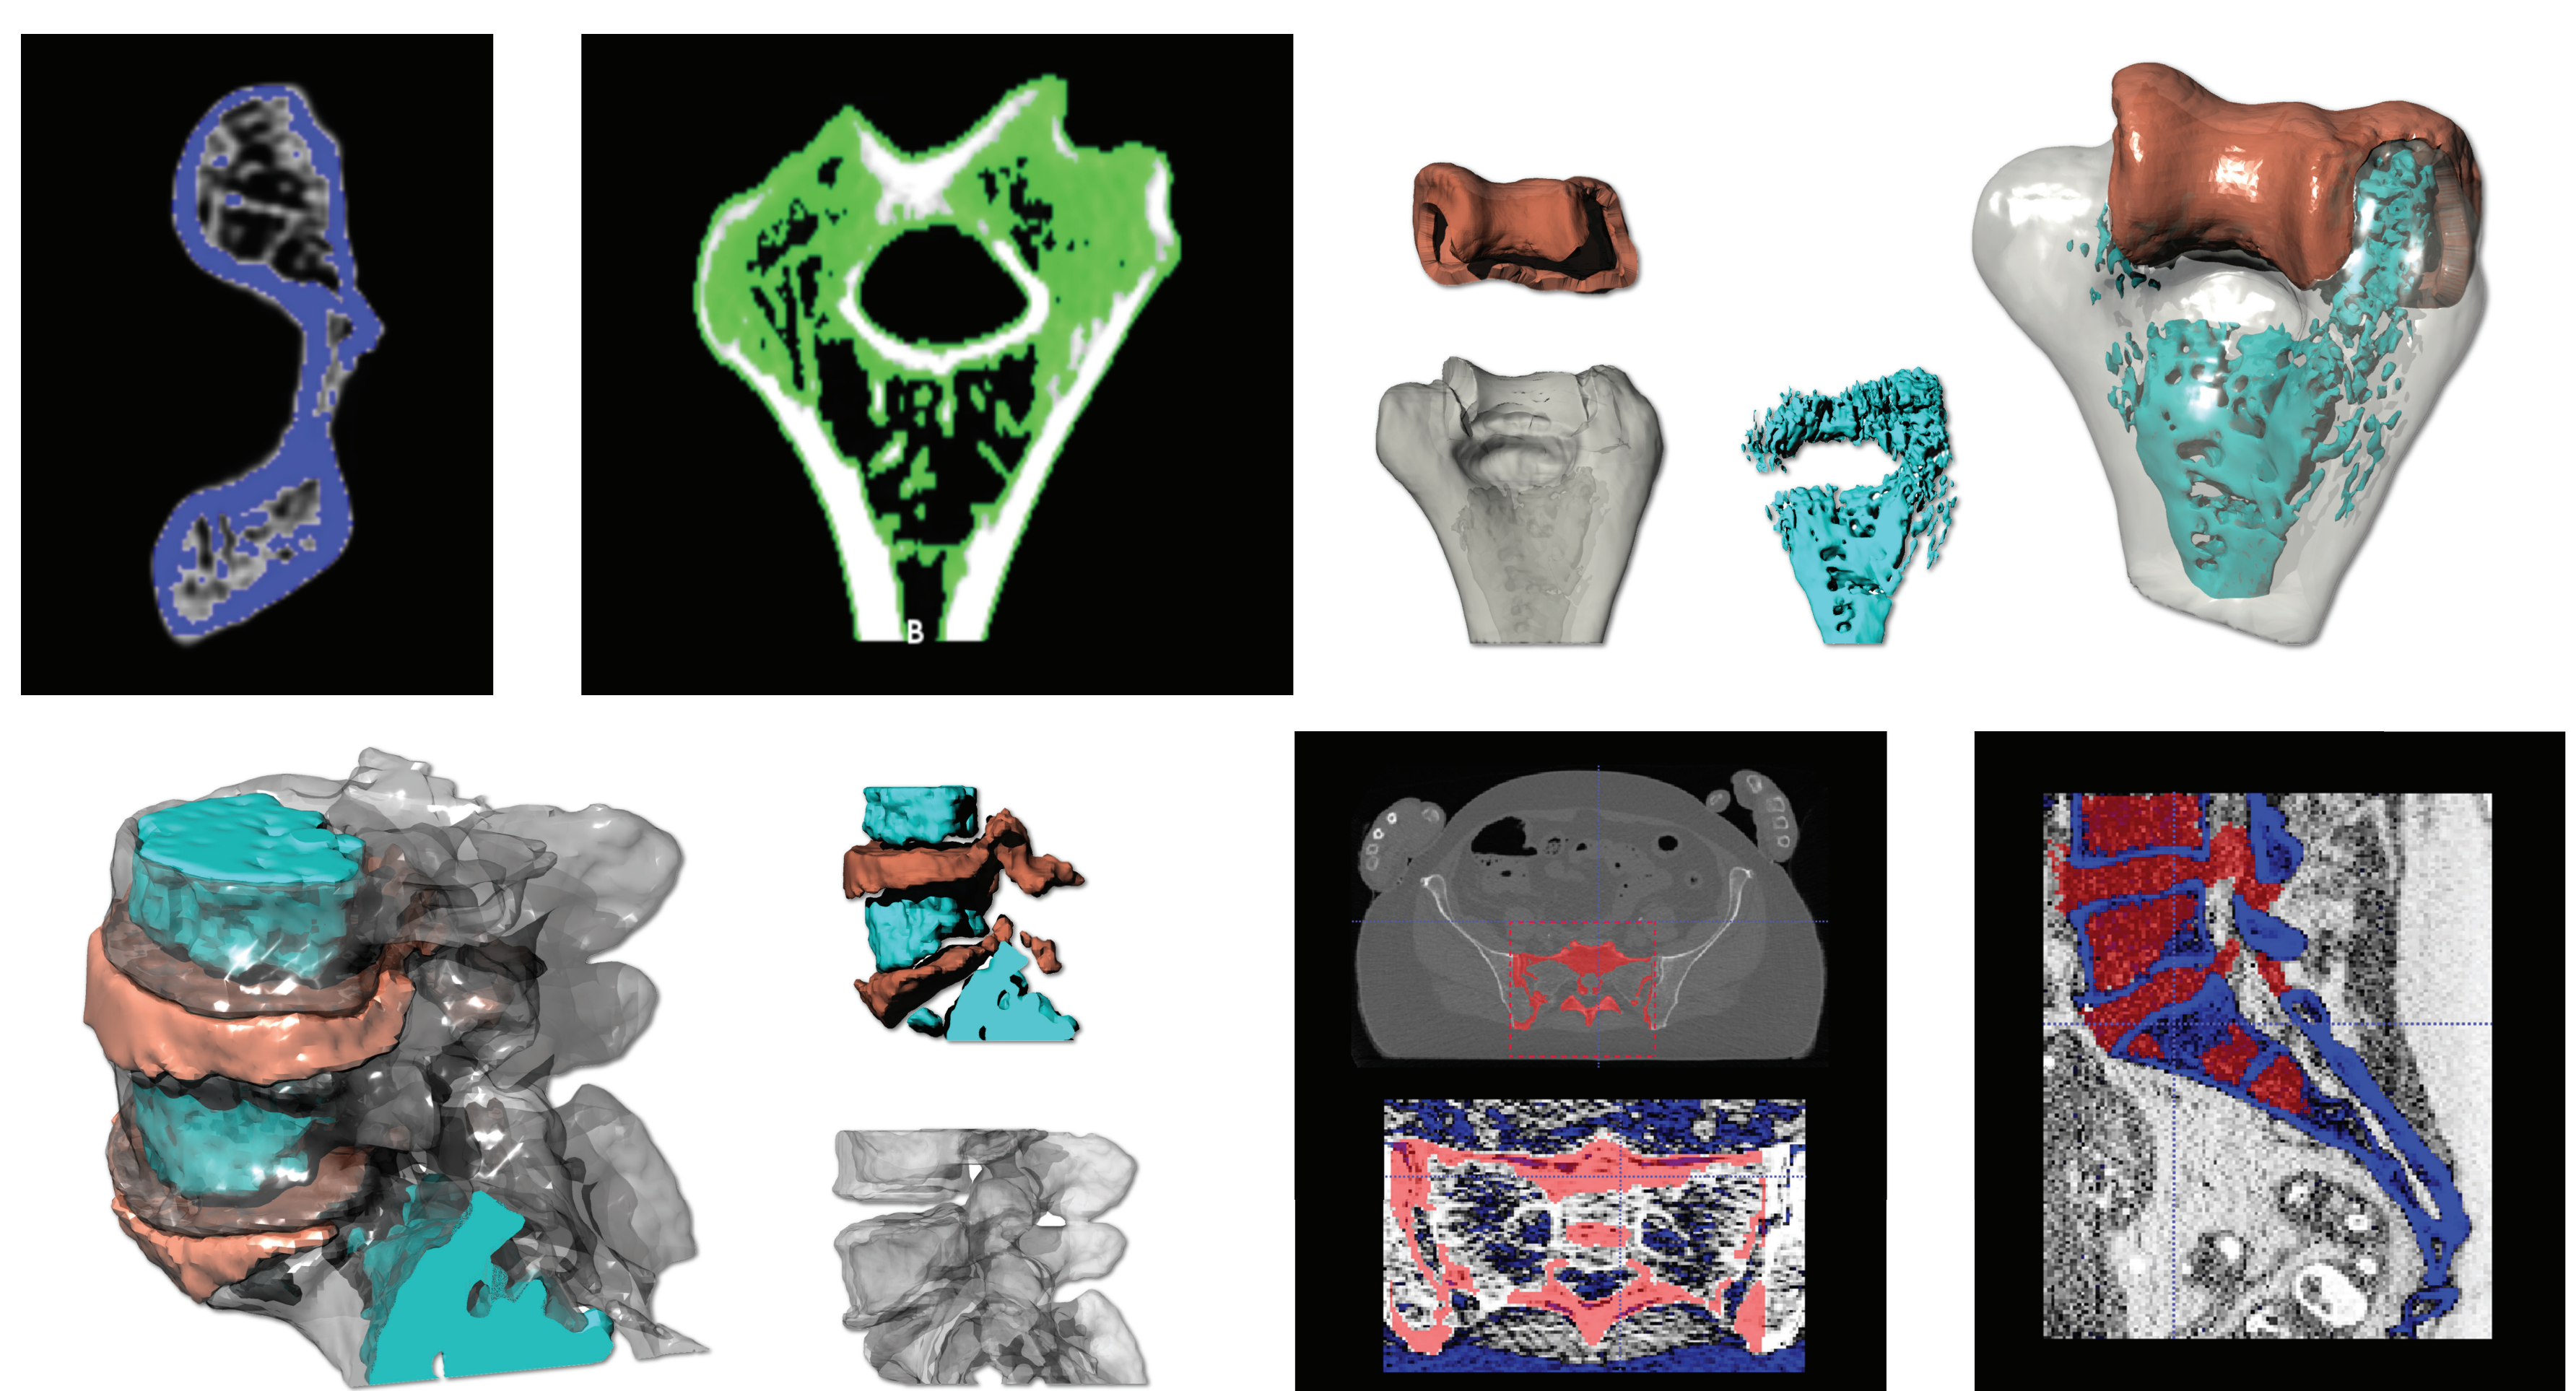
Clockwise from top left: Automatic segmentation of humeral epiphysis CT (cortical and spongy bone) using InVesalius; 3D surface reconstruction of humerus and lumbar region using Meshlab, Meshmixer, and Mudbox; Semi-automatic segmentation of pelvic region CT using ITK-SNAP.
